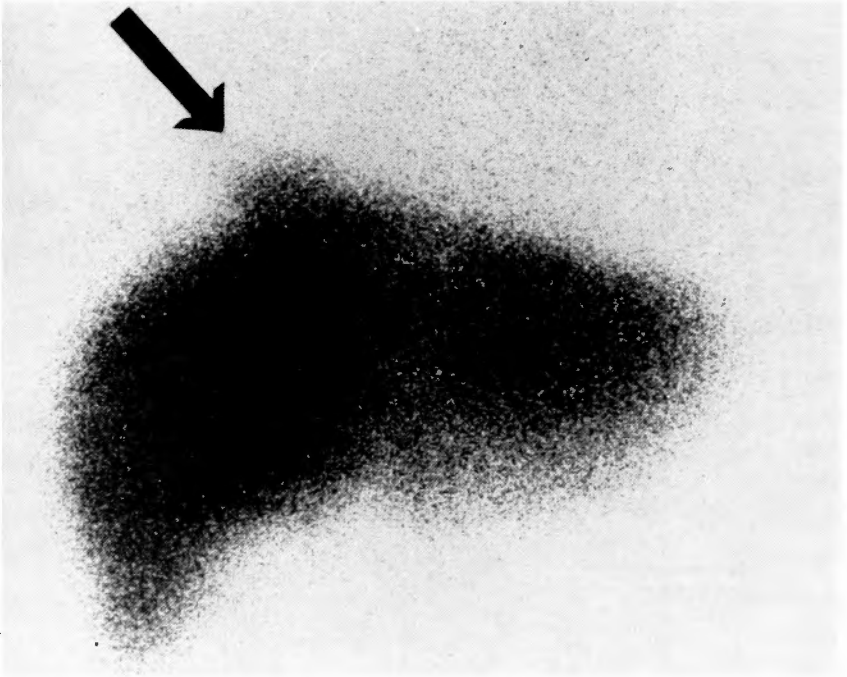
A liver scintigram is a postero-anterior view. A protrusion on the right lobe of the liver is clearly demonstrated.
